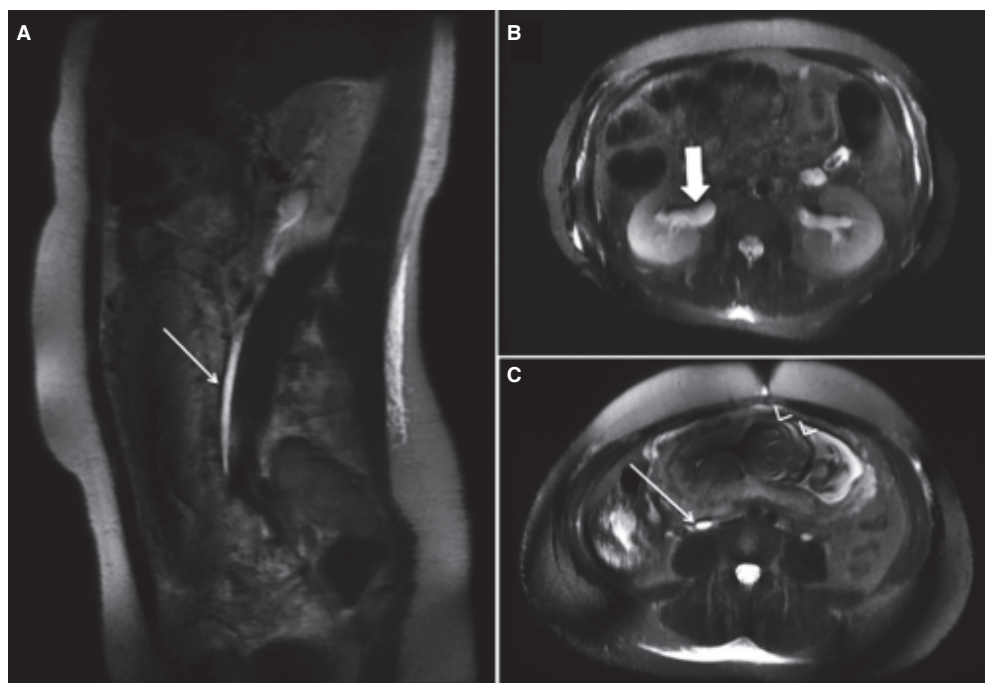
A. Sagittal MR image on FSE T2 weighted sequence demonstrate tapering of the distal right ureter due to pregnant uterus extrinsic compression without intraluminal hypointense images that suggest lithiasis. B. FSE T2 weighted axial image shows bilateral ureter dilatation in the right about 13 mm and in the left 8 mm in diameter, note is made of the voluminous uterus and the fetal head within at the pelvic cavity. C. Bilateral pyelocaliceal dilatation is also shown.
